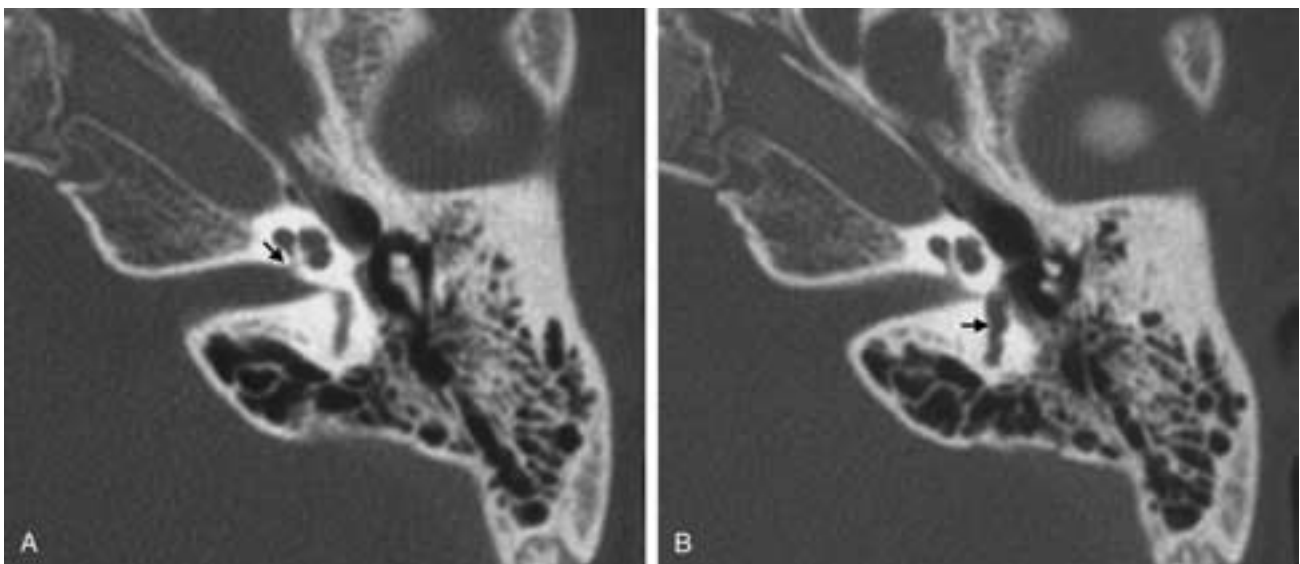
CHARGE association. A and B, Two contiguous axial CT images showing hypoplasia of the cochlear nerve fossa (*black arrow* in A) and a dysplastic vestibule (*black arrow* in B), with absence of the semicircular canals.
